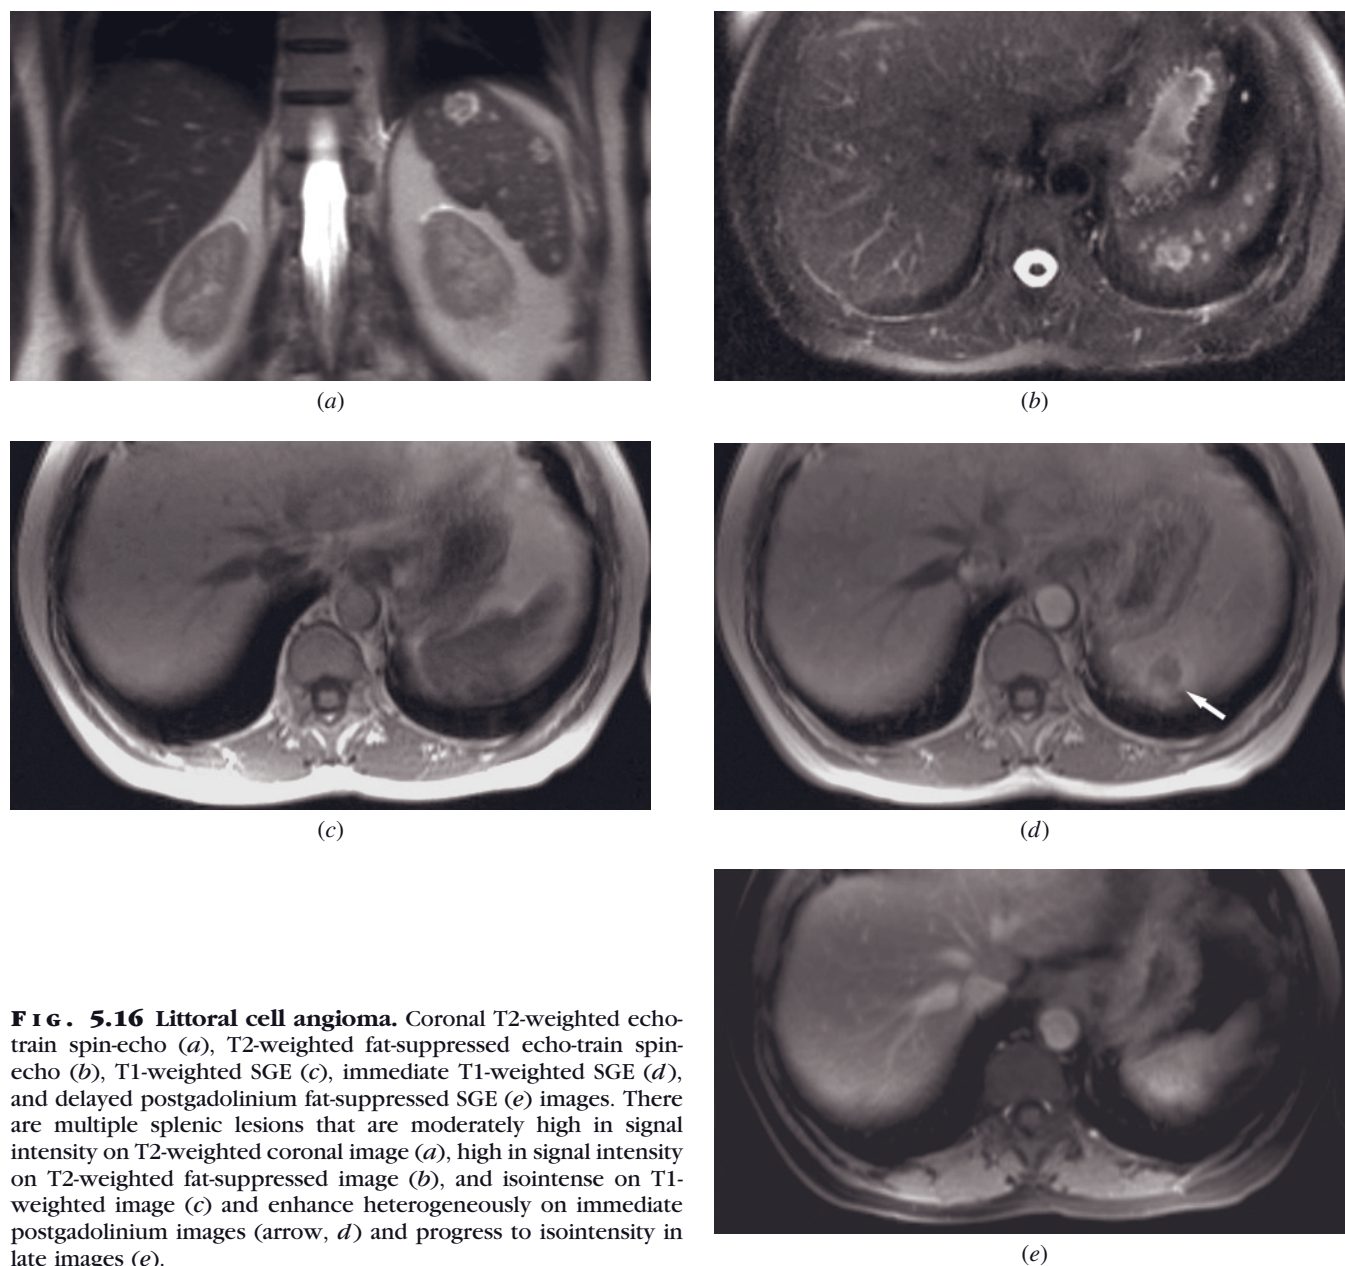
Littoral cell angioma. Coronal T2-weighted echo-train spin-echo (*a*), T2-weighted fat-suppressed echo-train spin-echo (*b*), T1-weighted SGE (*c*), immediate T1-weighted SGE (*d*), and delayed postgadolinium fat-suppressed SGE (*e*) images. There are multiple splenic lesions that are moderately high in signal intensity on T2-weighted coronal image (*a*), high in signal intensity on T2-weighted fat-suppressed image (*b*), and isointense on T1-weighted image (*c*) and enhance heterogeneously on immediate postgadolinium images (arrow, *d*) and progress to isointensity in late images (*e*).
